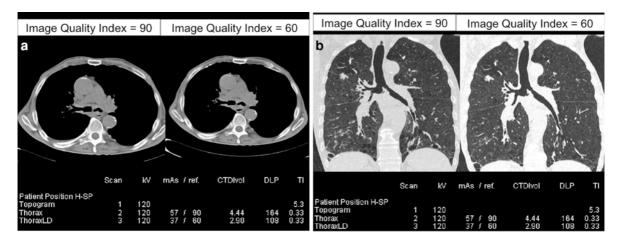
Side-by-side comparisons of unenhanced CT scans obtained in a 70-year-old underweight male patient with stage IV colon cancer and a BMI at 21 kg/m². The only modified parameter is the image quality index of the tube current modulation system. The first acquisition is performed with an index at 90 mAs (standard dose), whereas the second is obtained with the index set at 60 mAs (optimized dose), and a
